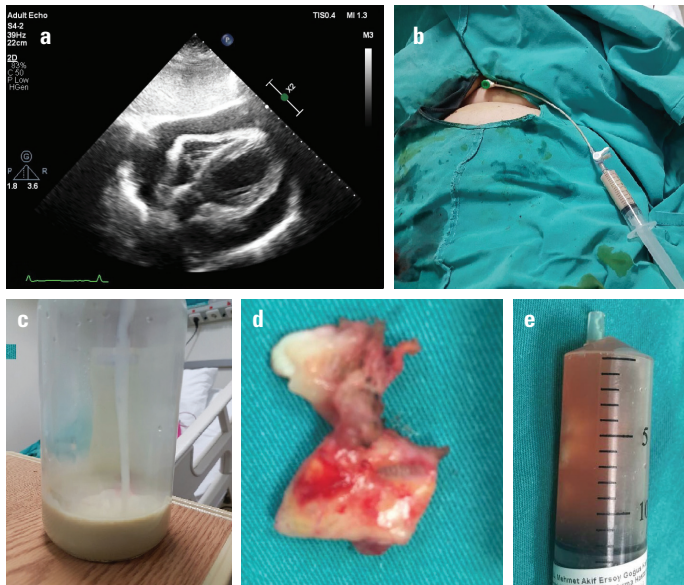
(a) Transthoracic echocardiography (subcostal view) showed massive pericardial effusion. (b) A 6F sheath was placed into the pericardial cavity via the subxiphoid approach. (c) A total of 300 mL of chylous effusion was drained. (d) 3x2 cm of thickened pericardium was excised during subxiphoid pericardiostomy. (e) Serous effusion was drained during subxiphoid pericardiostomy
